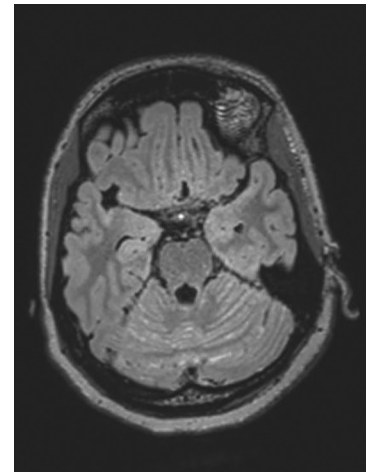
Mild sulcal FLAIR hyperintensity in bilateral occipital and superior cerebellar regions with smooth leptomeningeal enhancement (Pre-treatment).
